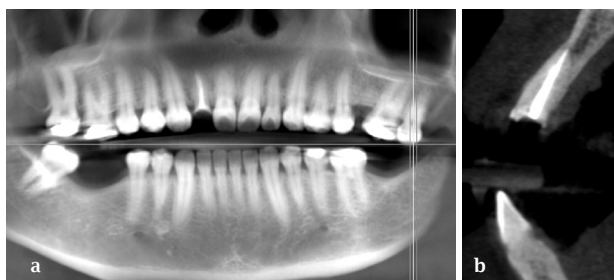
(a) Pre-operative radiographic view (b) Lateral View.
